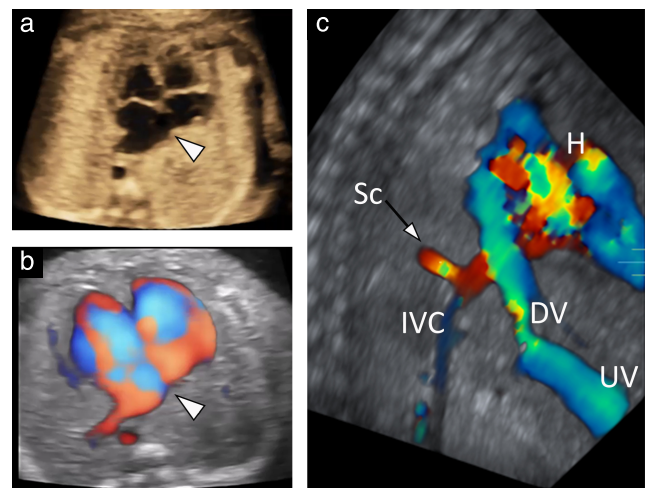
Imaging criteria used to diagnose scimitar syndrome in fetus (at 22 gestational weeks): (a) in four-chamber view, there is mesocardia due to moderately hypoplastic right lung and connection of right-sided pulmonary veins to left atrium is not visible (arrowhead); (b) on power Doppler, absence of right pulmonary venous drainage into left atrium is confirmed (arrowhead); and (c) on spatiotemporal image correlation, three-dimensional color Doppler reconstruction demonstrates scimitar vein (Sc) draining into inferior vena cava (IVC). DV, ductus venosus; H, heart; UV, umbilical vein.
